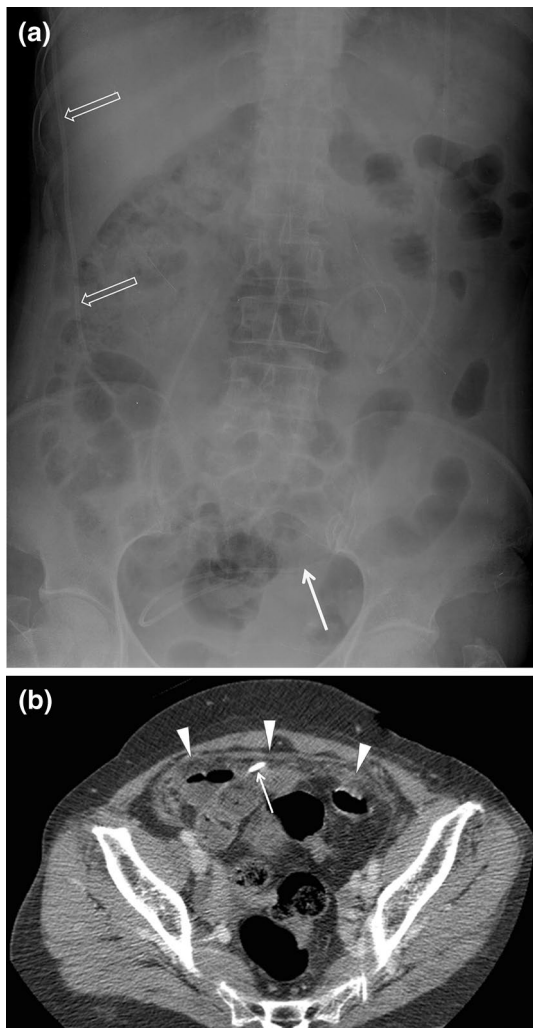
Infection of a fractured peritoneal segment of a ventriculo-peritoneal shunt catheter in a 61-year-old female with hydrocephalus who had recent abdominal pain. a Abdominal radiograph shows a fractured segment (*arrow*) of a ventriculo-peritoneal shunt catheter in the pelvic cavity, which is from the *right* side shunt catheter (*open arrows*). The finding of infection cannot be identified in this plain radiograph. Note the newly inserted ventriculo-peritoneal shunt catheter in the *left* side of the abdomen. b Axial CT scan shows dirty infiltration in the greater omentum (*arrowheads*) adjacent to a fractured segment of the shunt catheter (*arrow*), suggesting shunt catheter-related peritonitis. Micrococcus species grew from the shunt catheter
